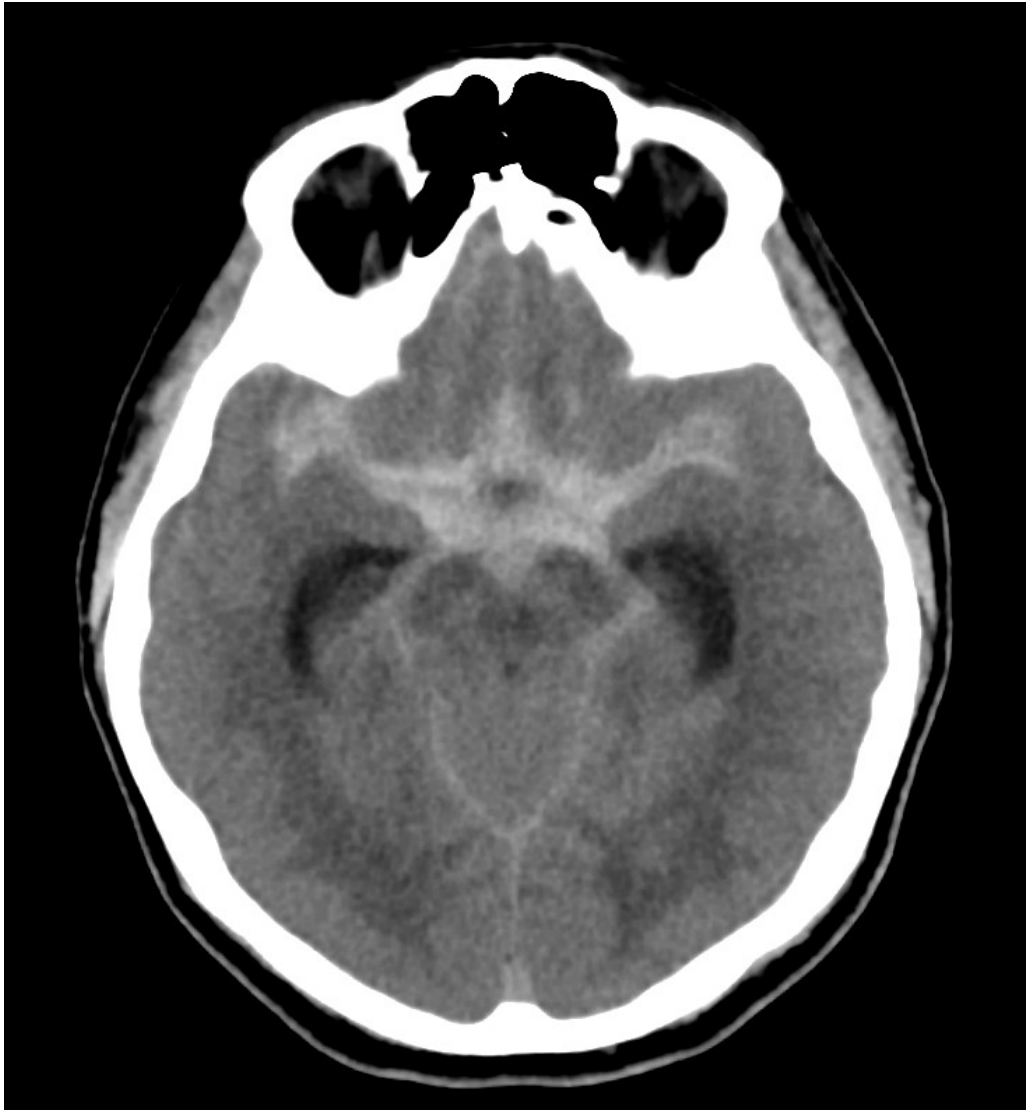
A non-contrast cranial CT shows an extensive SAH. (Source: James Heilman, MD, A subarachnoid hemorrhage, Wikimedia Commons, License: CC BY-SA 3.0, <https://commons.wikimedia.org/wiki/File:SubarachnoidP.png>)
